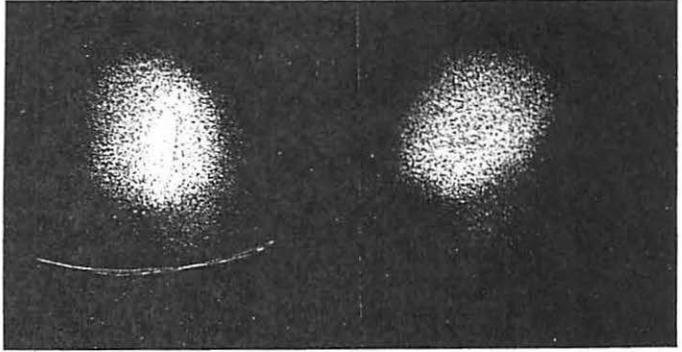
Camera scintigraphy of the spleen in left lateral (*left*) and posterior (*right*) position, 30 minutes after injection of 200 μCi ^{197}Hg BMHP damaged red blood cells. In the posterior position below the spleen, activity in the left kidney.
